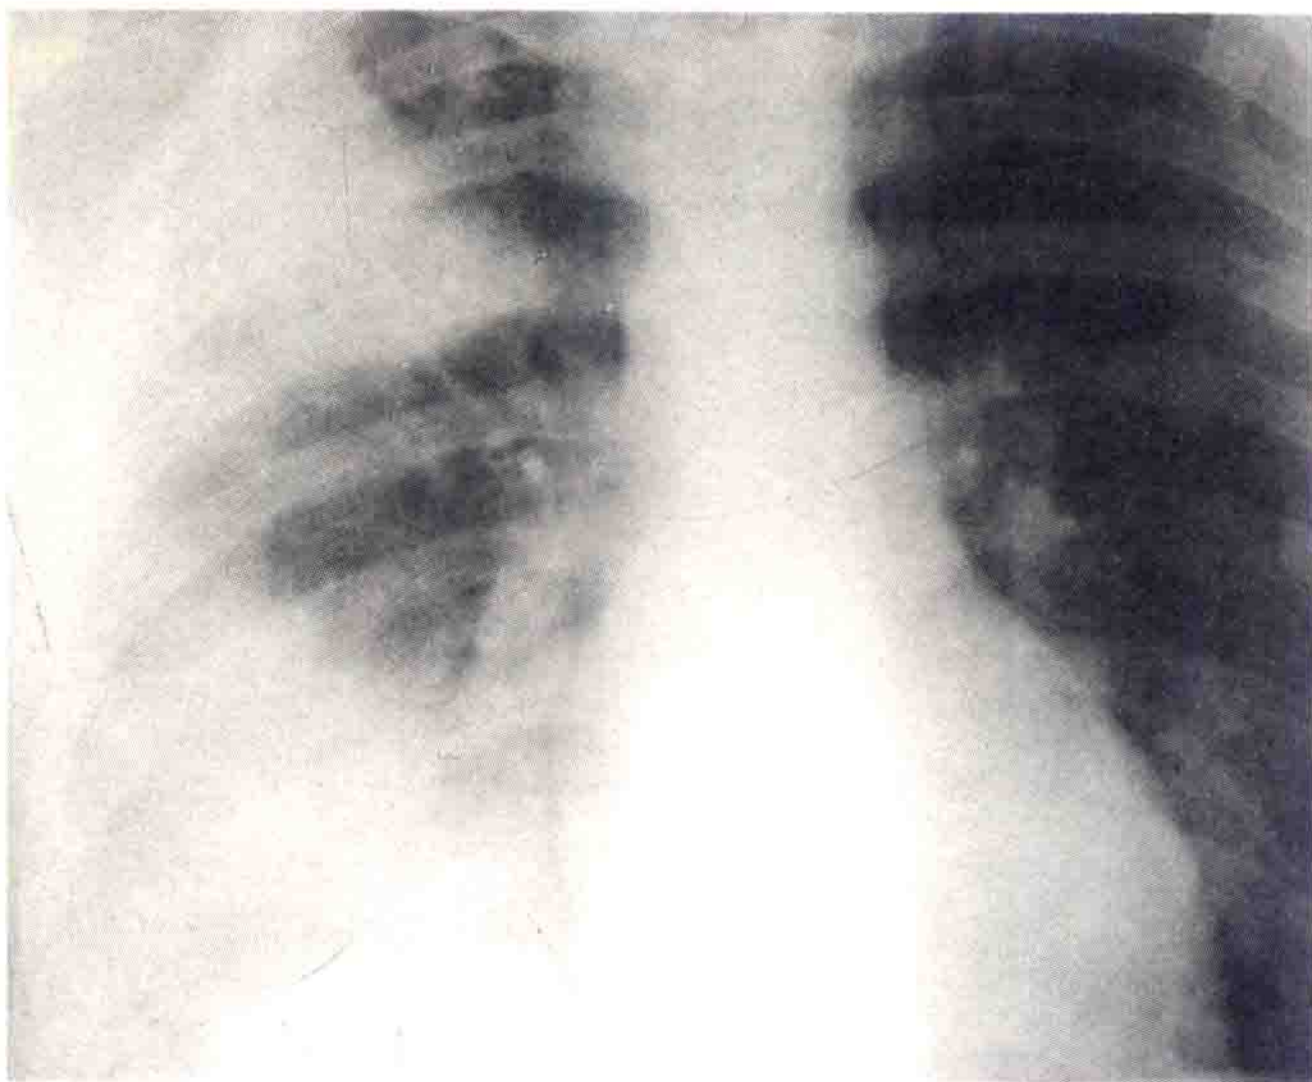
Legionnaire's disease. This patient, a previously healthy man aged 43 years, became infected in Spain. He had a stormy course with prolonged high fever, severe pneumonia and, in the early stages, diarrhoea and a toxic confusional state. This chest radiograph shows his predominantly right lower and right upper lobe pneumonia. *Legionella pneumonophila* infection was proved serologically.
